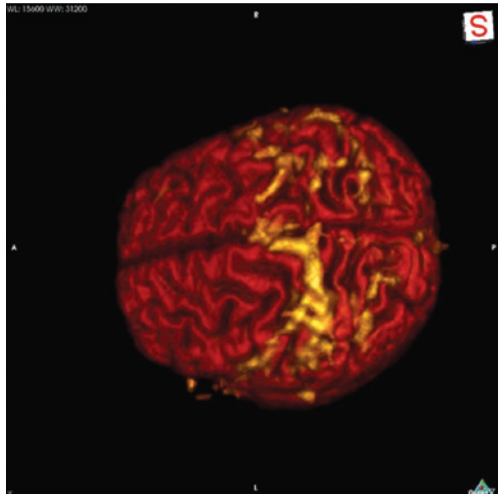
Example of a 3D image of the fusion of structural and functional magnetic resonance images of the motor area. The locations at which the greatest signal change was detected are shown in yellow
